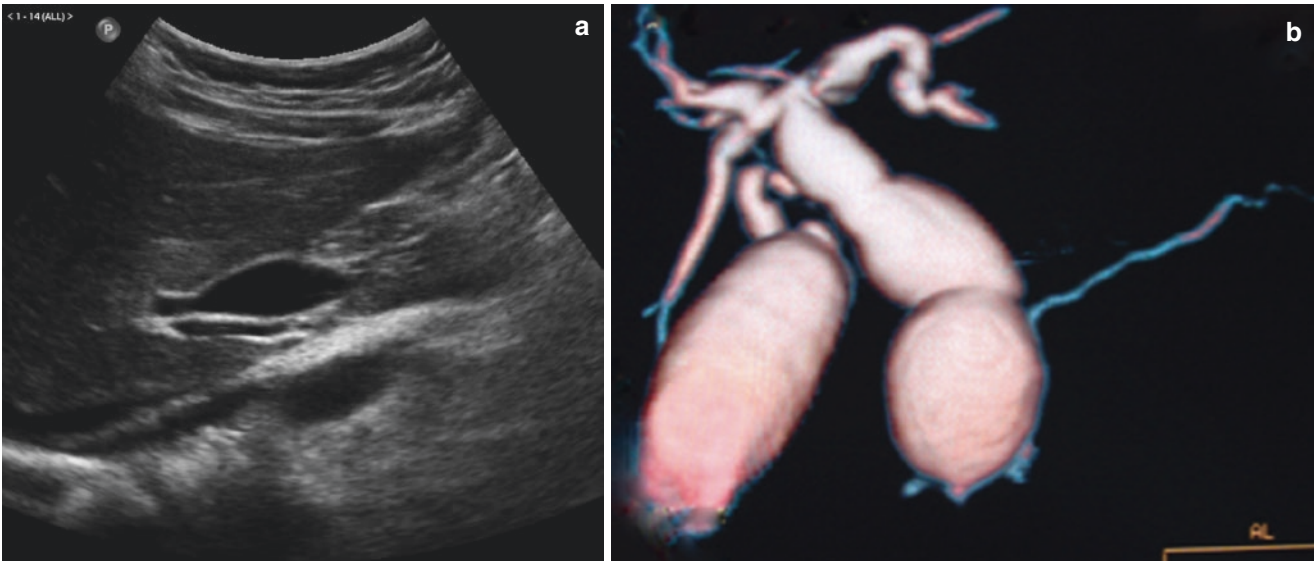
(a) Ultrasound of the abdomen. A single sagittal view set obliquely demonstrating fusiform dilatation of the common bile duct, a type 1 choledochal cyst. (b) A coronal reconstruction of an MRCP demonstrating fusiform dilatation of a type 1 choledochal cyst. (c) Choledochal cyst; different view of b. (d) A preoperative study showing contrast injected through the gallbladder demonstrates an enlarged biliary system and a choledochal cyst causing obstruction and tapering to a fine stream in an attempt to enter into the duodenum
